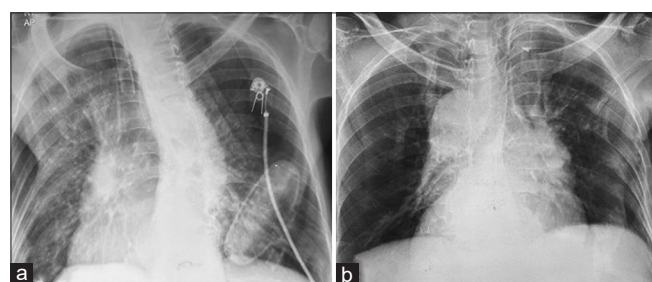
Chest radiography on days 2 and 4 showed clearance of infiltrates (a and b, respectively)
